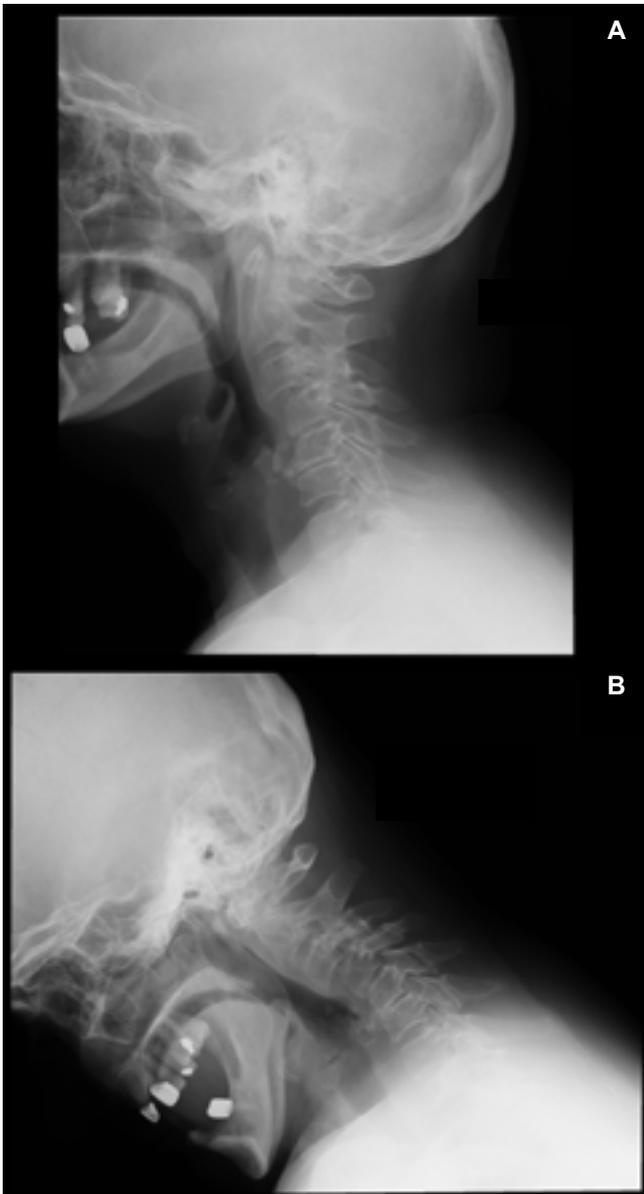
X-radiograph of the cervical segment before cervical spine stabilization surgery: neutral position (A), flexion (B). Date of examination: November 19, 2018.
